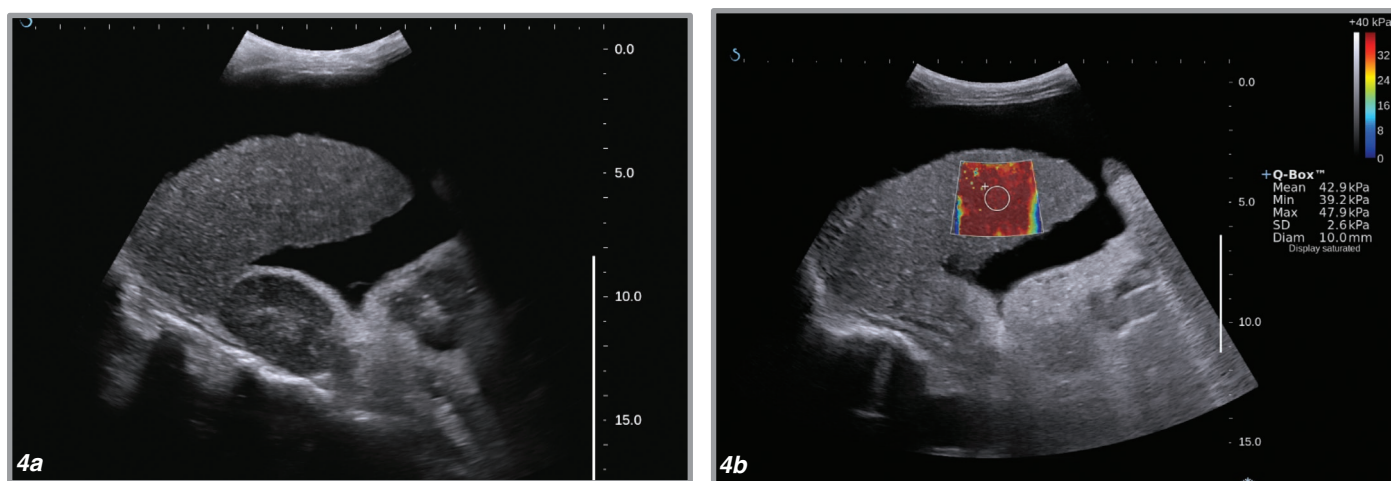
A 61 year-old man with liver cirrhosis. a. Shrunken liver with surface nodularity and a large amount of ascites was clearly seen on B-mode ultrasound. b. On ShearWave Elastography, mean elasticity was 42.9 kPa. No correlation to biopsy was available for this patient.
